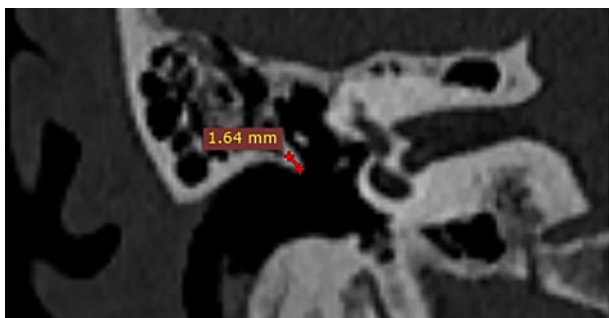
The right coronal cut of the pre-operative high-resolution computed tomography image shows a completely accessible stapes footplate (type I), angle 98.6° and length 1.64 mm.
